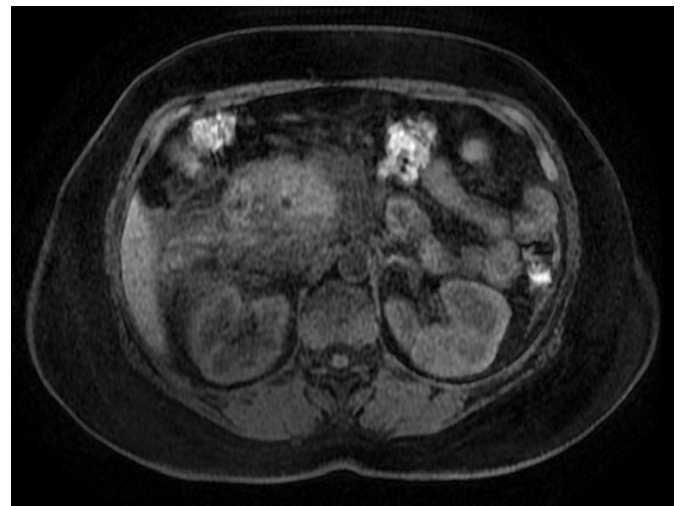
MRI of the abdomen showed prominent inflammatory changes surrounding the pancreas. Common bile duct measuring up to 5 to 5.5 mm. There are large heterogeneous fluid collections in the pararenal space of the right kidney.
